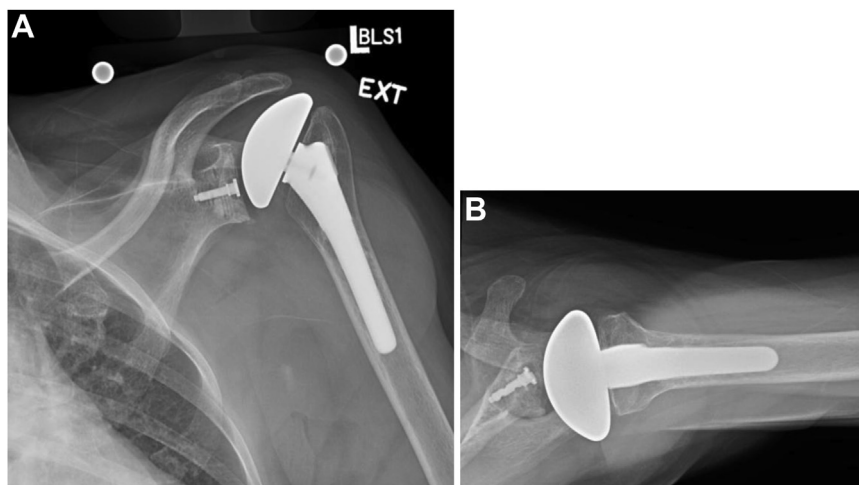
(A) demonstrates an anteroposterior view of the left glenohumeral joint with radiographic evidence of superior humeral head migration. (B) is a lateral view of the left shoulder with posterior subluxation of the humeral component.
